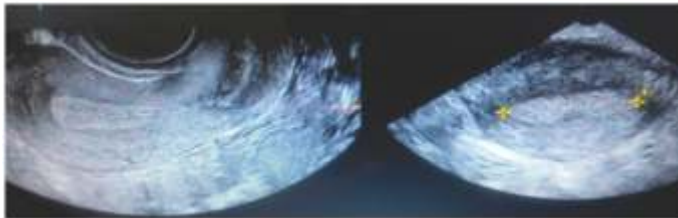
Dual image on B mode ultrasound showing mid saggital plane of uterus in one box and transverse section of uterus measuring endometrial length in transverse section.
